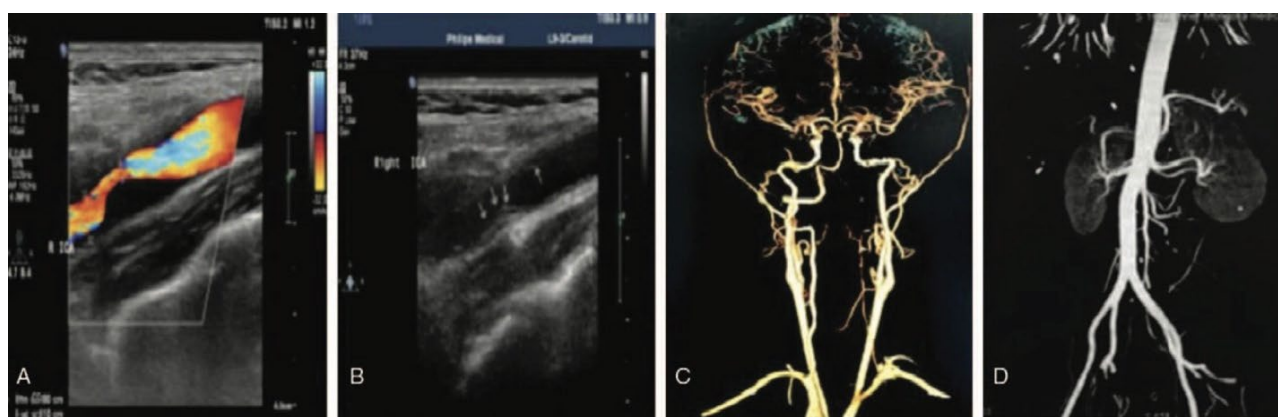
A) Carotid ultrasound revealed high-grade stenosis of the right C2 segment of the Internal Carotid Artery (ICA) [17]; B) The stenosis was suggested by the formation of hematoma after an intimal rupture (arrow); C) CT Angiography image (CTA) demonstrates collateral circulation; D) On follow-up, no further aneurysms were observed in the CTA of the abdominal aorta [17].
